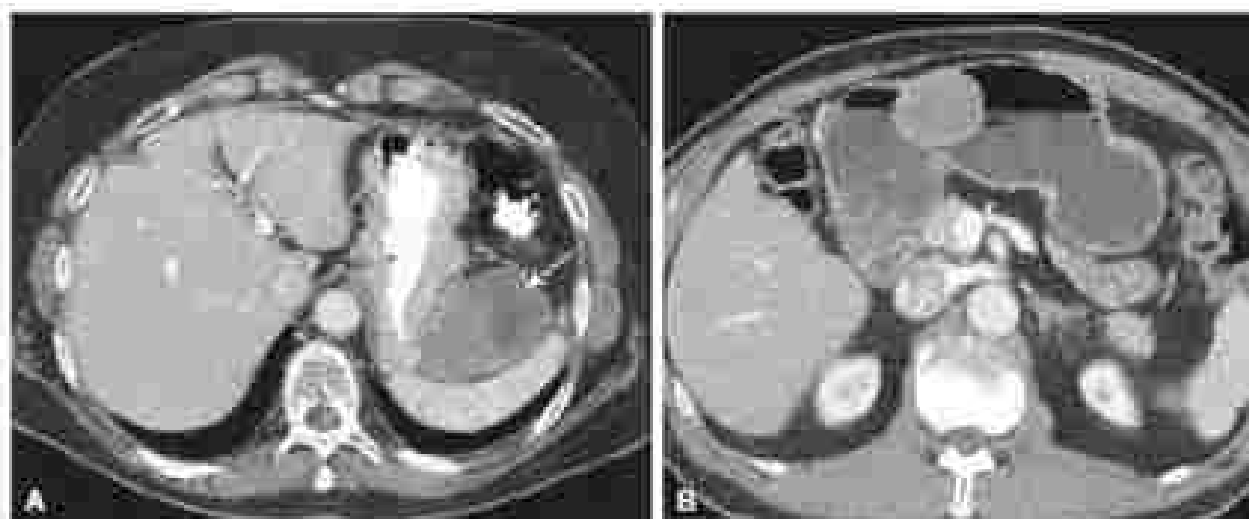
Contrast-enhanced computed tomography scan of a patient with a gastrointestinal stromal tumor (GIST). (A) The most common appearance is soft-tissue or solid imaging. (B) Indolent GISTs of the stomach are less common but may be associated with higher rates of recurrent disease and bleeding.
